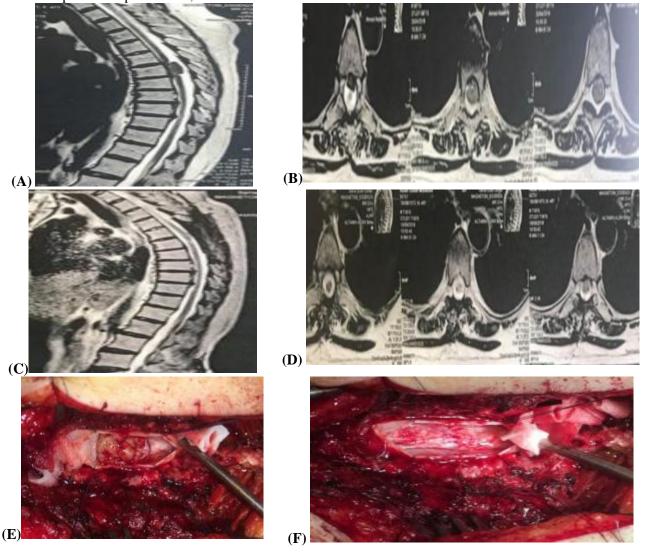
A 48 years old female patient who had surgery for lumbar spondyloleithesis, she had initial improvement before she developed new symptoms after 1 year of surgery. She had recurring severe lower back pain (VAS 10) but with LL spasticity and hyperreflexia, then she had progressive LL weakness to grade 3 right side and grade 4- left side (Frankel grade C) and sphincteric dysfunction. MRI thoracic spine revealed IDEM tumor at D6 level with severe cord compression. Surgery was done with laminectomy, complete tumor excision was done. Postoperatively, patient had improved to full power bilaterally (Frankel grade E). she had full sphincteric control, and the lower back pain improved to VAS 1. [A-D: MRI dorsal spine, pre-operative (A, B) and post-operative (C, D), E, F: intra-operative images show pre IDEM tumor excision (E) and post excision (F)].
